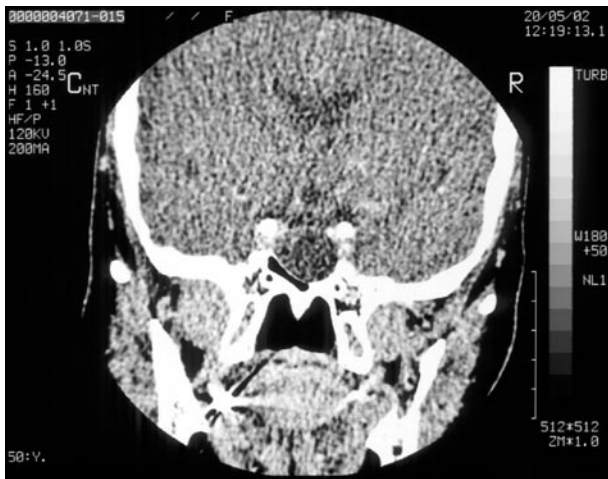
Contrast enhanced computed tomography showed a water density intrasellar mass, which was not enhanced with contrast medium.
